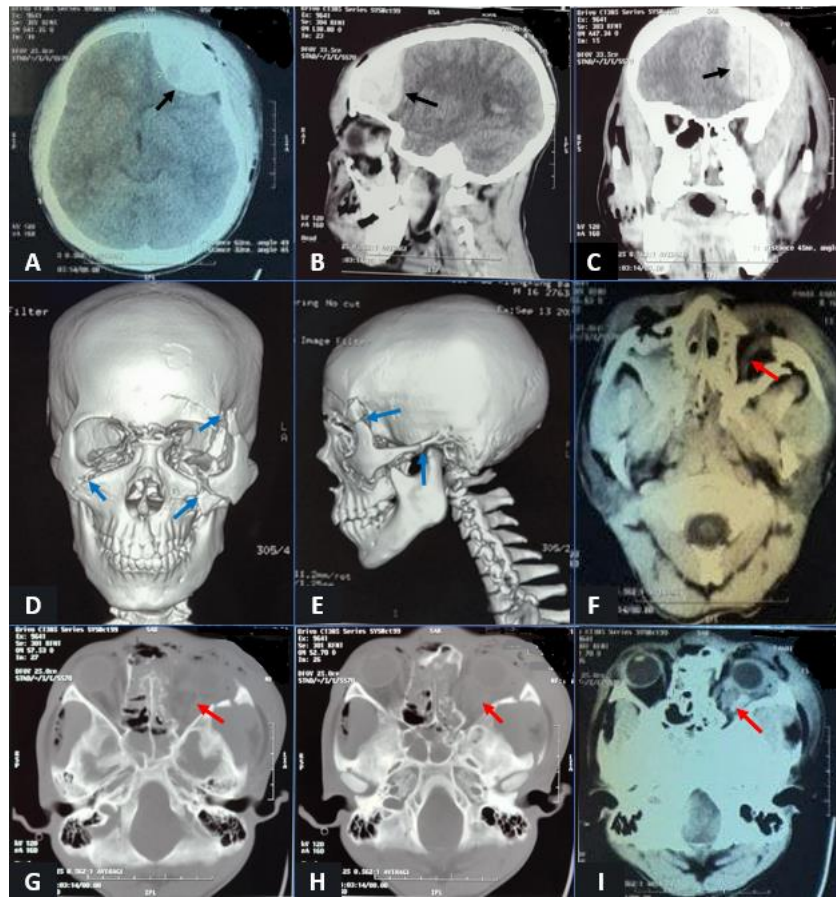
Head CT-scan with 3D reconstruction.
